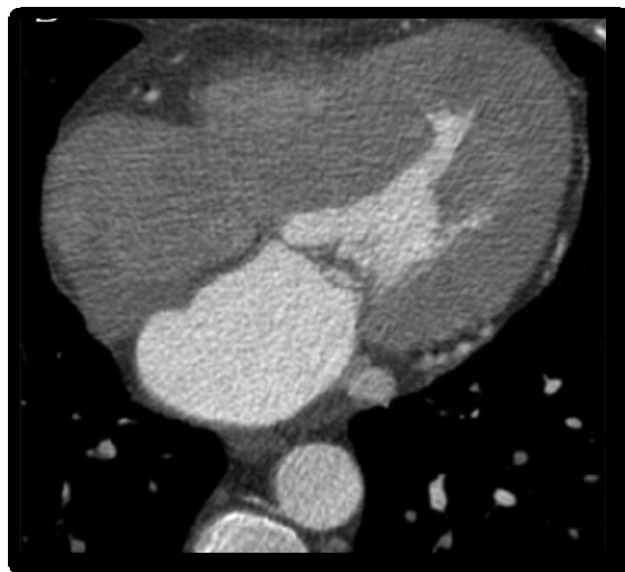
Cardiac CT - Hypertensive cardiomyopathy with concentric LV hypertrophy
